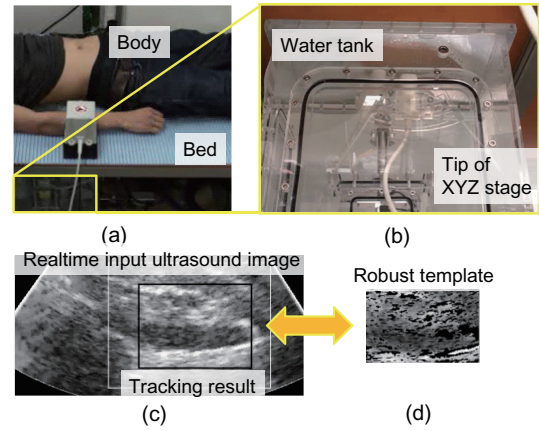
Experimental environment of realtime tracking and following of kidney. (a) Human body and bed, (b) Water tank and tip of XYZ stage, (c) Real-time input ultrasound image and tracking result, (d) Proposed robust template.
